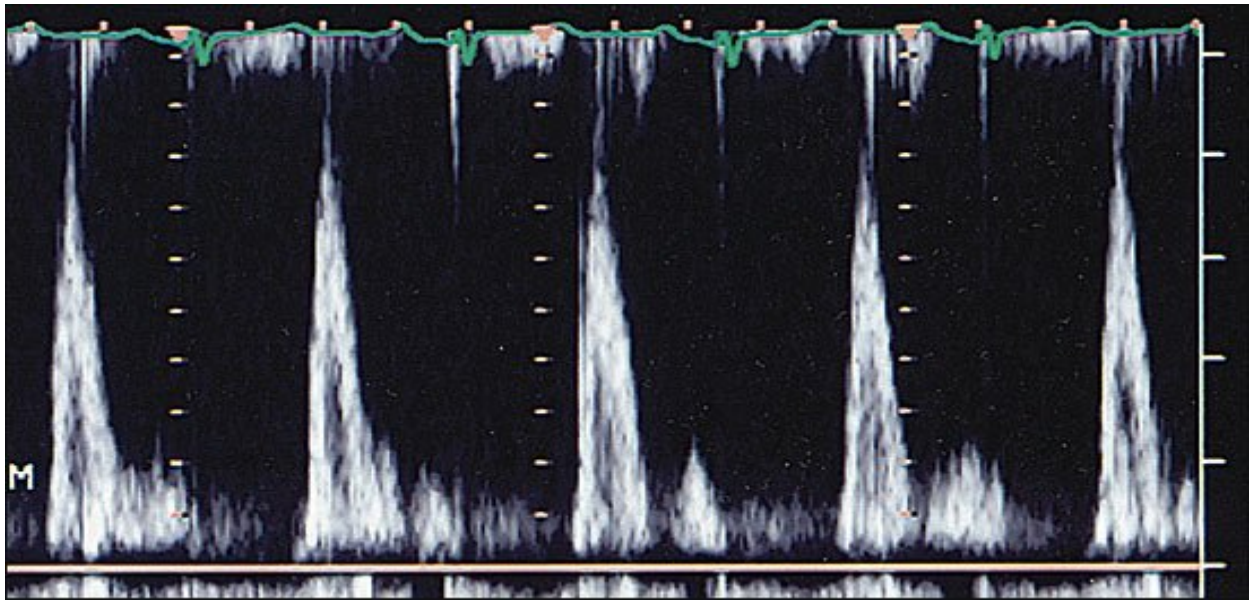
Trans-mitral-valve Doppler flow pattern in a patient with severe (restrictive) diastolic dysfunction. The E-to-A-wave ratio is abnormally high, and the A-wave velocity is extremely low.
